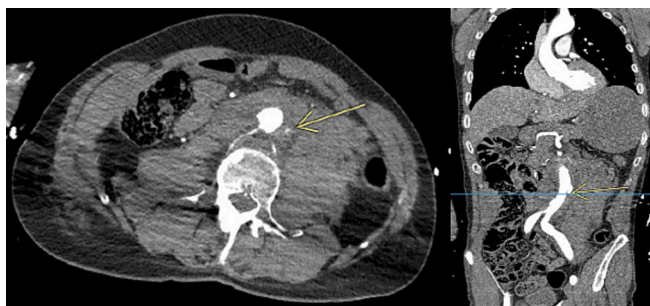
Initial contrast enhanced trauma CT showing a large retroperitoneal hematoma and an active hemorrhage from a focal dissection of the infrarenal aorta.
